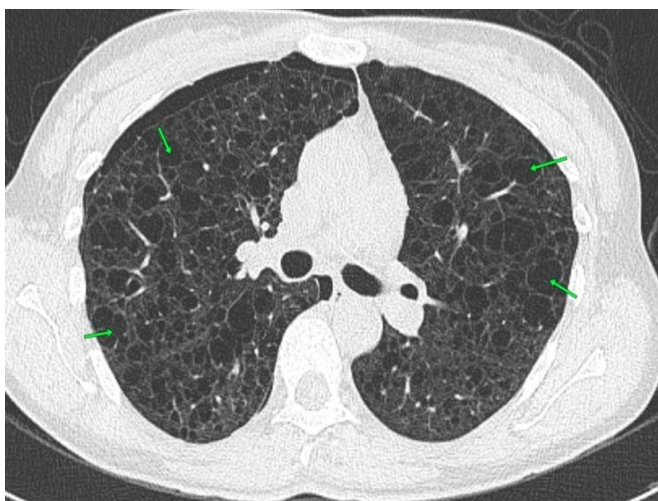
Transverse cut of chest CT scan showing numerous, thin-walled, air-filled cysts of varying sizes (green arrows) with surrounding normal parenchyma signifying a diffuse cystic lung disease
